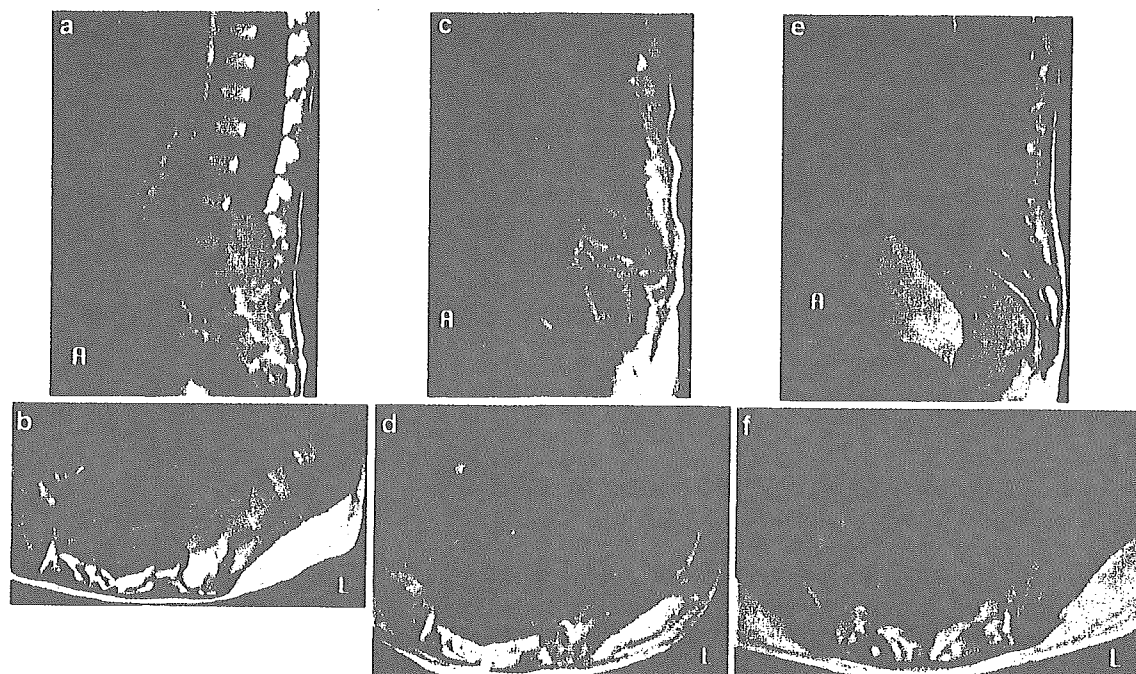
a,b At the time of the initial admission, sagittal and coronal T1-weighted MRI scans showed an epidural mass filling the spinal canal below L3 and extending into the left abdominal cavity. c,d At the time of the second admission, the tumour had increased in size, compared to the images obtained 3 months earlier. e,f The size of the tumour shrunk remarkably after six courses of chemotherapy
